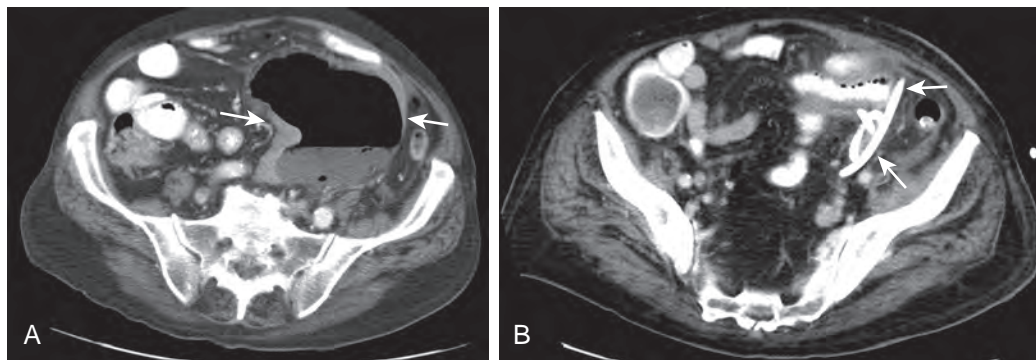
Percutaneous drainage of diverticular abscess. A. Contrast-enhanced CT image shows a large diverticular abscess (arrows) in a 51-year-old woman. B. Axial CT image obtained 2 weeks after percutaneous drainage shows complete collapse of the diverticular abscess cavity (arrows).
